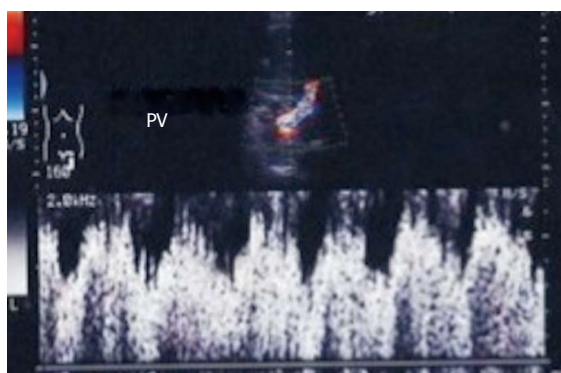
Post-biopsy arterio-venous fistula. Color Doppler image demonstrating a pulsatile portal vein branch in segment 6 subsequent to a post-biopsy arterio-venous fistula. PV: Portal vein.
